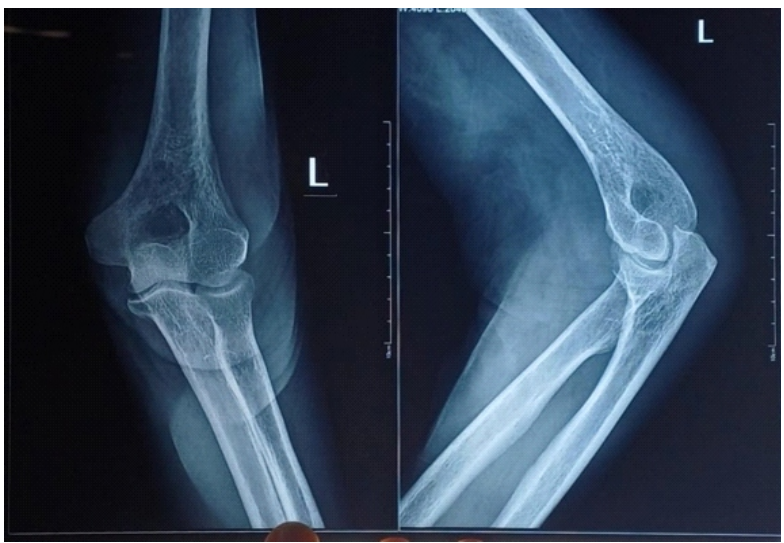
Plain radiograph of the left elbow (anteroposterior and lateral views) showing preserved joint alignment with no obvious fracture or gross bony destruction.
